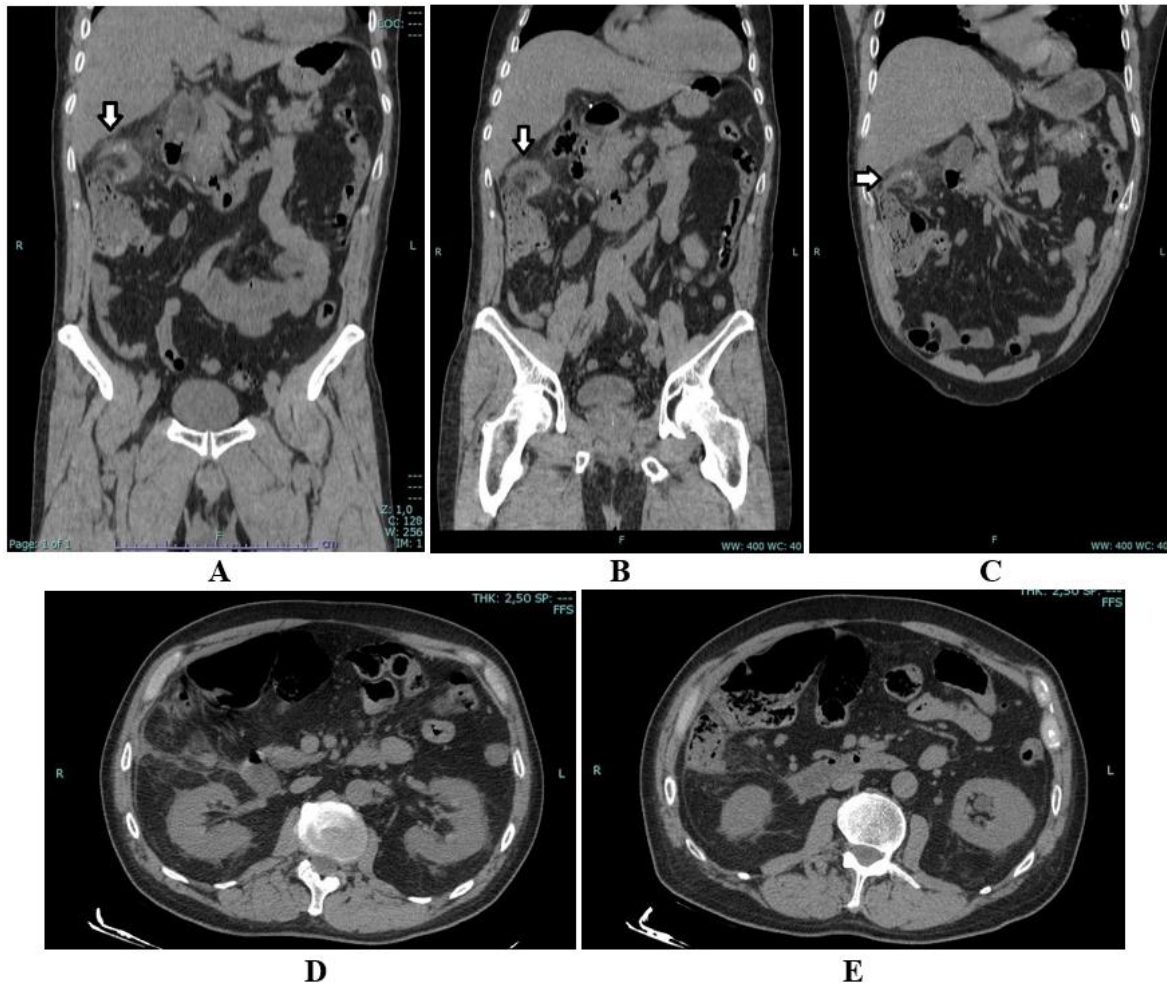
Basal abdominal CT scan. A) Coronal and B, C) oblique reconstructions show appendix “hook like” with thickened walls (arrows), originating from the ascending colon with some appendicoliths in the lumen. D) Axial reconstructions show the Gerota's fascia whit edematous imbibition and a perivisceral fluid layer. E) Lymphadenopathies in adjacent location.
